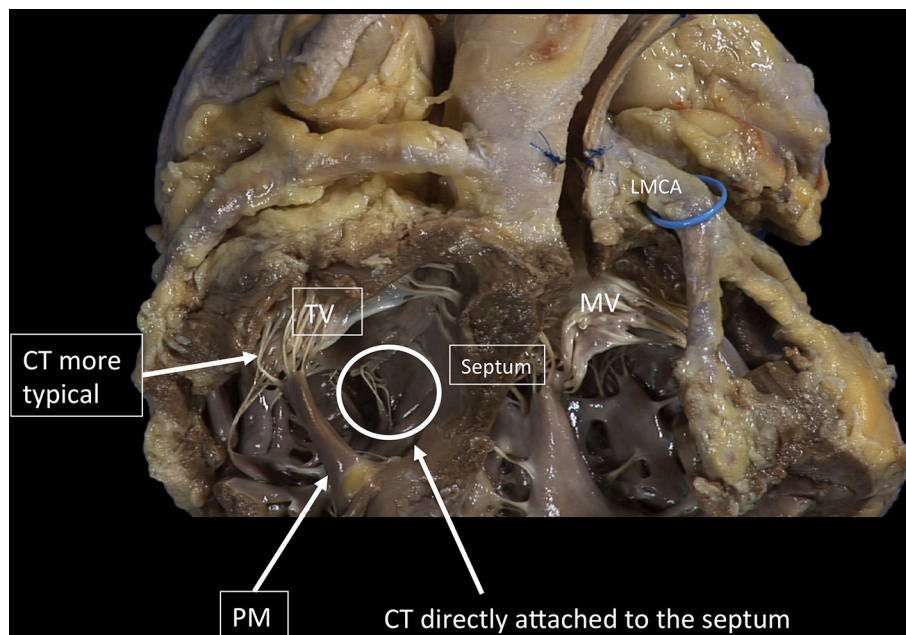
The TV has a more complex chordal structure in comparison to MV. The chordae can be attached directly to the RV wall and septum, differently from the LV. On average, a number of 25 chordae inserts into the TV. The chordal system is hierarchical similar to the left one, dividing the types of chordae in basal, intermediary or secondary chordae and the marginal chordae, attaching to the free edges. The attachment of the marginal or primary chordae is usually single on the right, without bifurcating or trifurcating close to the edge and originating from various levels of the papillary muscles. Even if thinner, the chordae of the TV commissures are trifurcated with a characteristic fan-like disposition. CT, Chordae tendineae; PM, papillary muscle; MV, mitral valve; TV, tricuspid valve. LMCA, left main coronary artery (light blue circle). Courtesy of Dr. M. Reisman, University of Washington.
